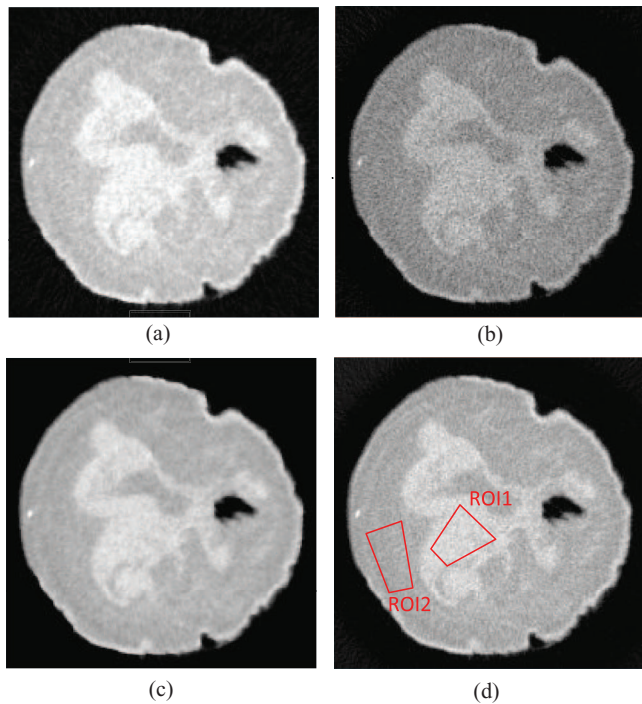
A CT slice of a postmortem breast reconstructed using (a) TFIR with 204 projections, (b) FBP with 204 projections, (c) TFIR with 614 projections and (d) FBP with 614 projections. The images were adjusted to the same window and level. The two polygons indicate the ROIs selected from glandular (ROI1) and adipose (ROI2) tissues to calculate CNR.
